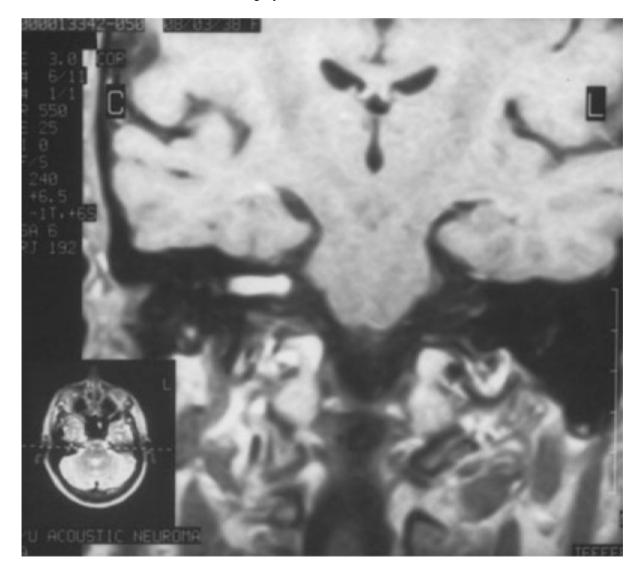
T1-weighted contrast–enhanced magnetic resonance imaging scan of a right acoustic neuroma extending toward the fundus, filling the internal auditory canal. The transverse crest is not well outlined.
